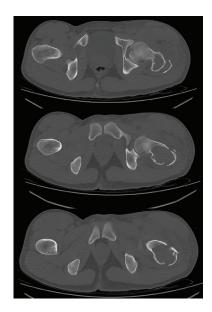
These representative axial cuts of computed tomography (CT) scans taken after the second month of Denosumab show an intact medial cortex.
